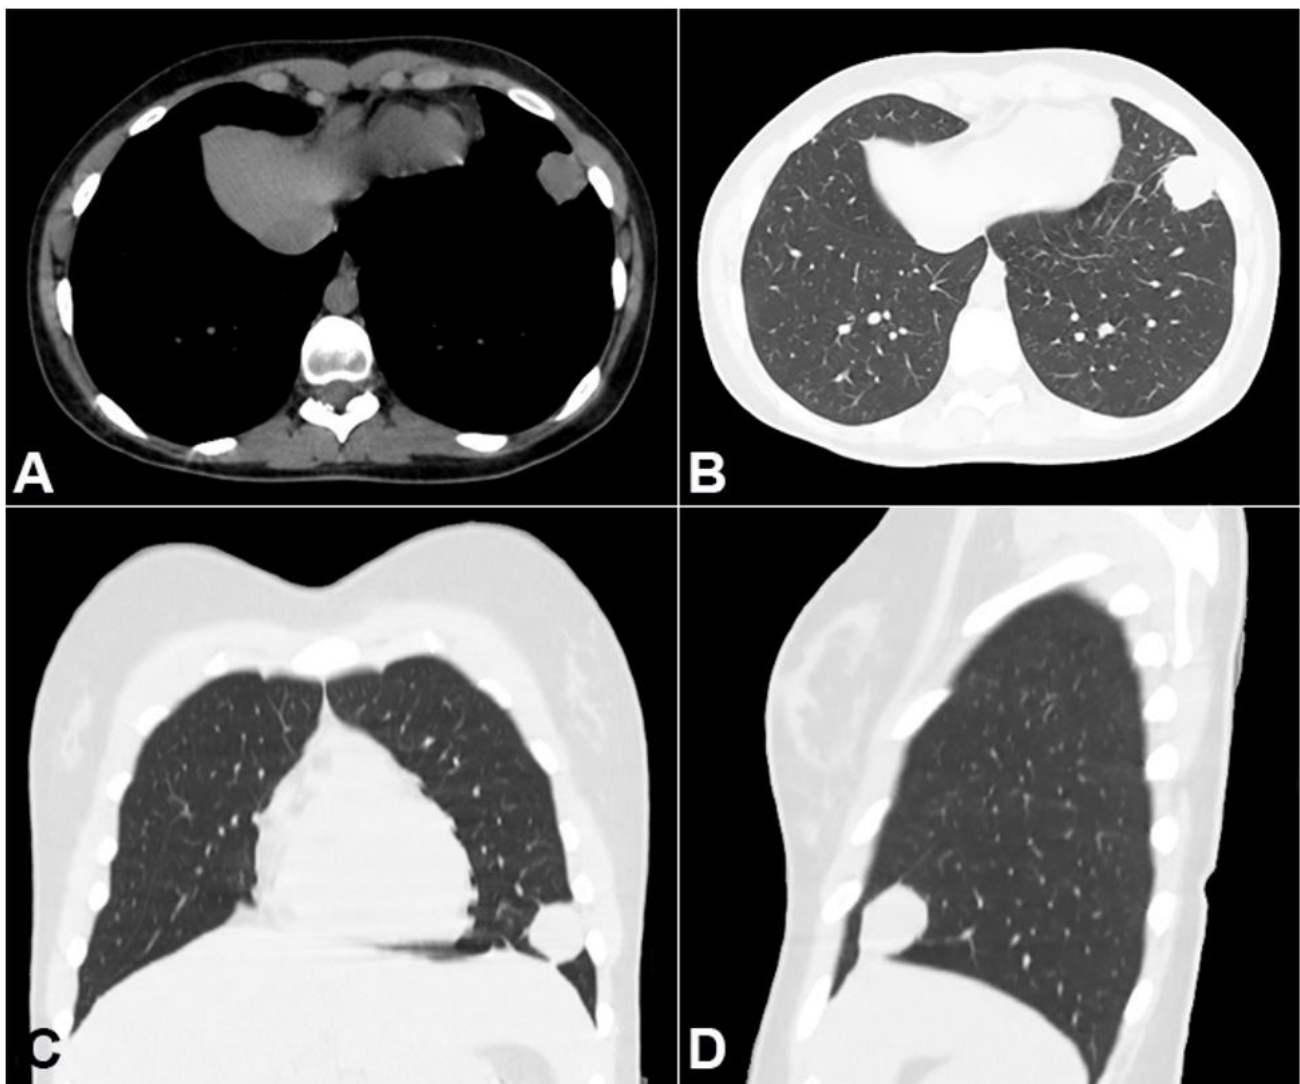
Thoracic computed tomography. A and B – Axial plane; C – coronal plane; D – sagittal plane showing a hyperattenuating juxtapleural lesion in the anterior segment of the left lower pulmonary lobe.
